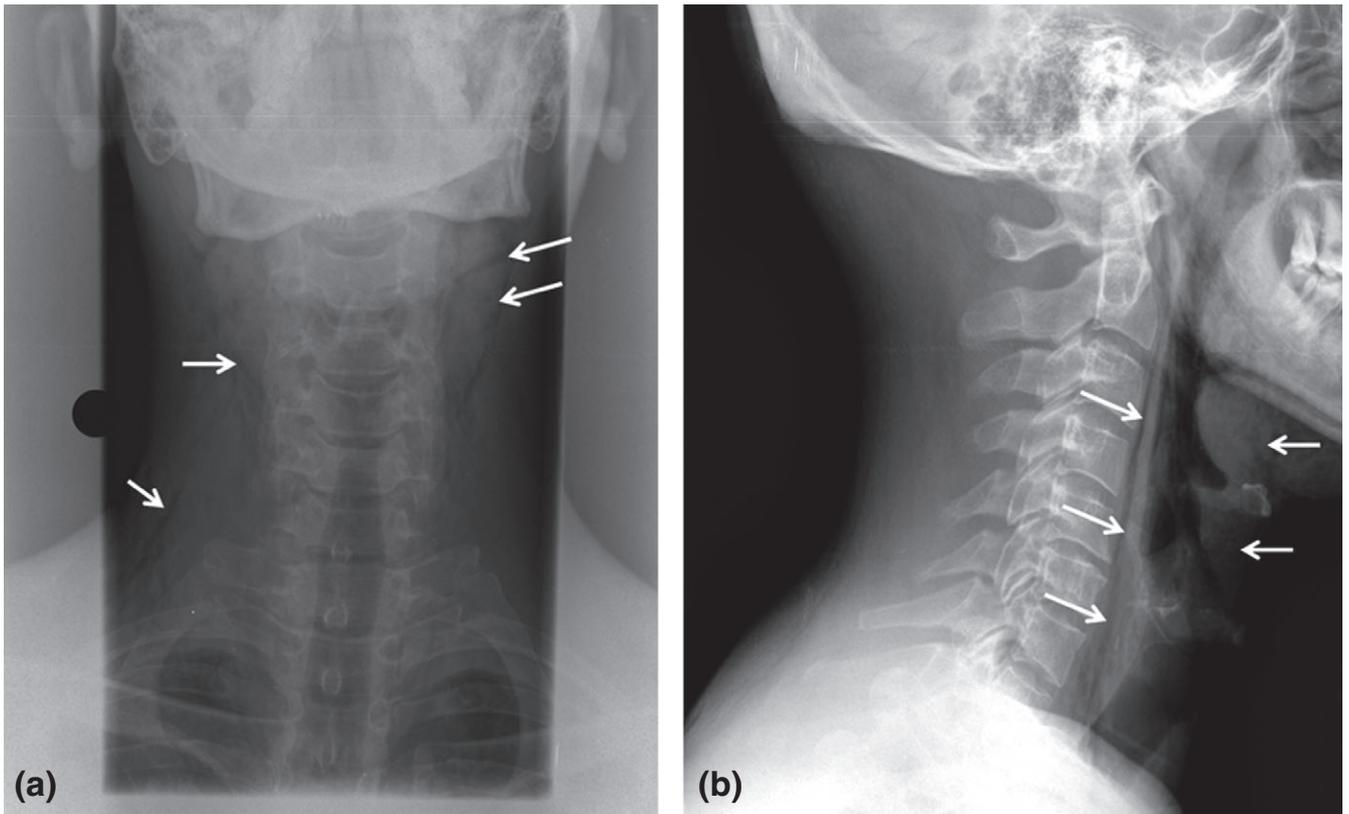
(a) Anteroposterior and (b) lateral X-rays of the neck showing cervical spread of the subcutaneous emphysema (arrows).
